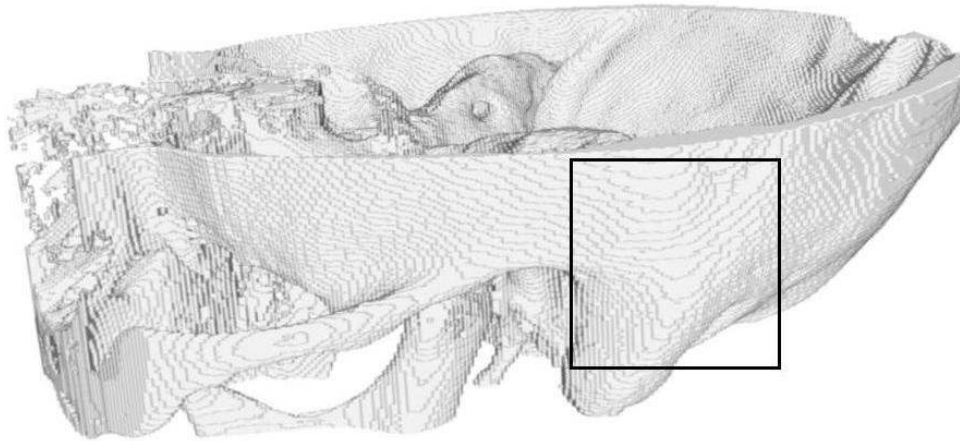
Surgical site. Mastoidectomy is performed in the region indicated by the rectangle. CT data courtesy of dr. Emanuele Neri, Division of Diagnostic and Interventional Radiology, University of Pisa.
